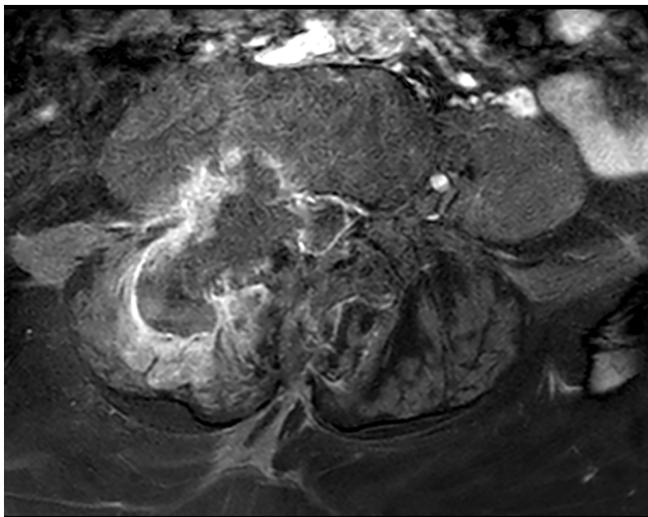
T1 weighted post-contrast axial MRI image through the lesion demonstrates central non-enhancement. Appearances were initially interpreted as a collection, hence infection was the initial proposed diagnosis.
